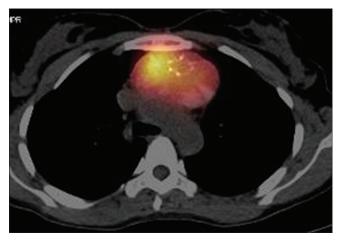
Single-photon emission computed tomography/computed tomography of chest showing increased uptake localized to anterior mediastinal mass lesion
